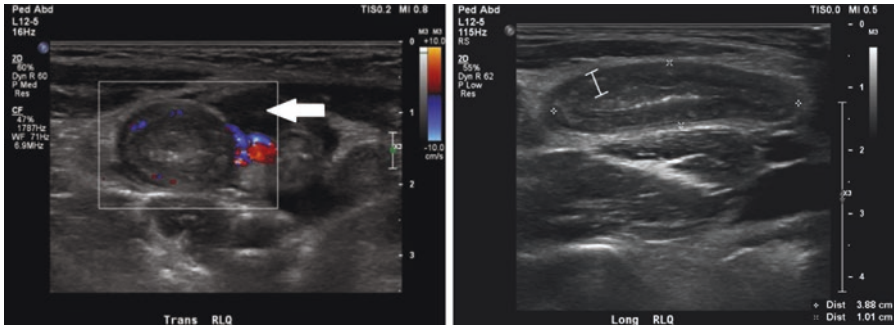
Ultrasound positive for appendicitis. Transverse view (left) demonstrates periappendiceal free fluid (arrow). Longitudinal view (right) highlights appendiceal wall thickening, with a maximal outer diameter of 1.01 cm
